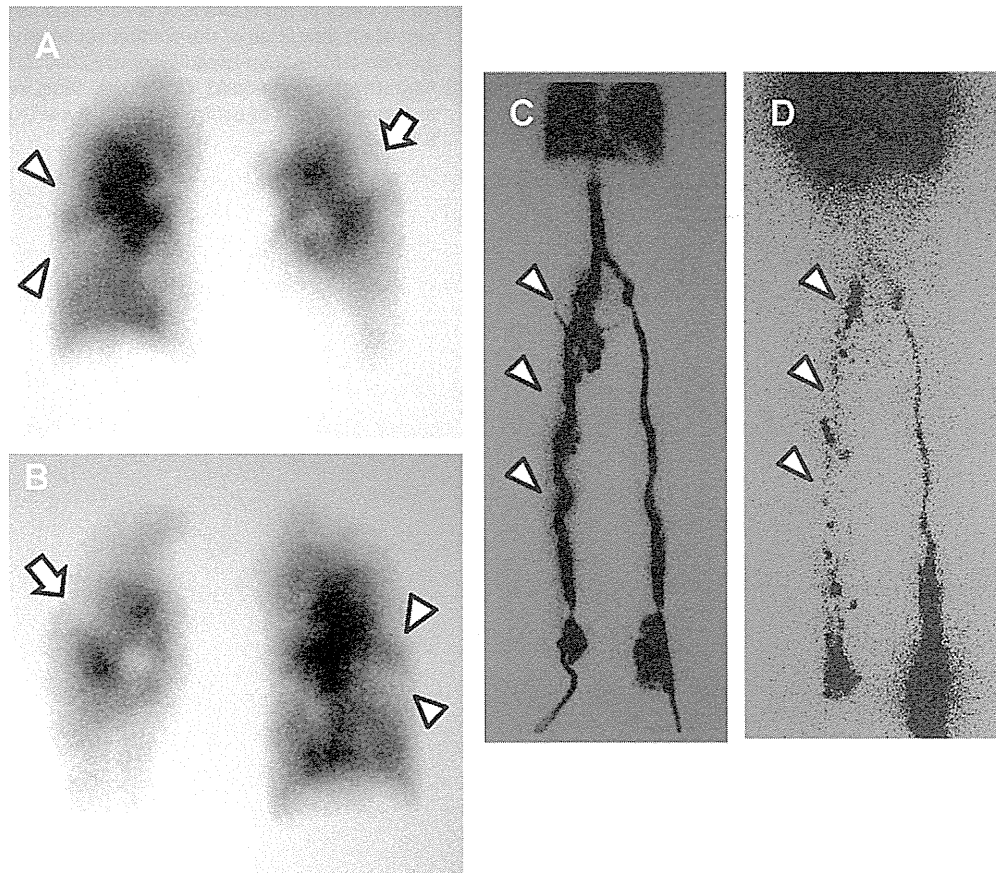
Pulmonary perfusion scintigraphy showed filling defects in both lung [A (anterior view) and B (posterior view)]. Perfusion scintigraphy of lower extremities showed a delay of disappearance of ^{99m}Tc -MAA in his right leg compared to his left leg [C (early phase) and D (delay phase)].
